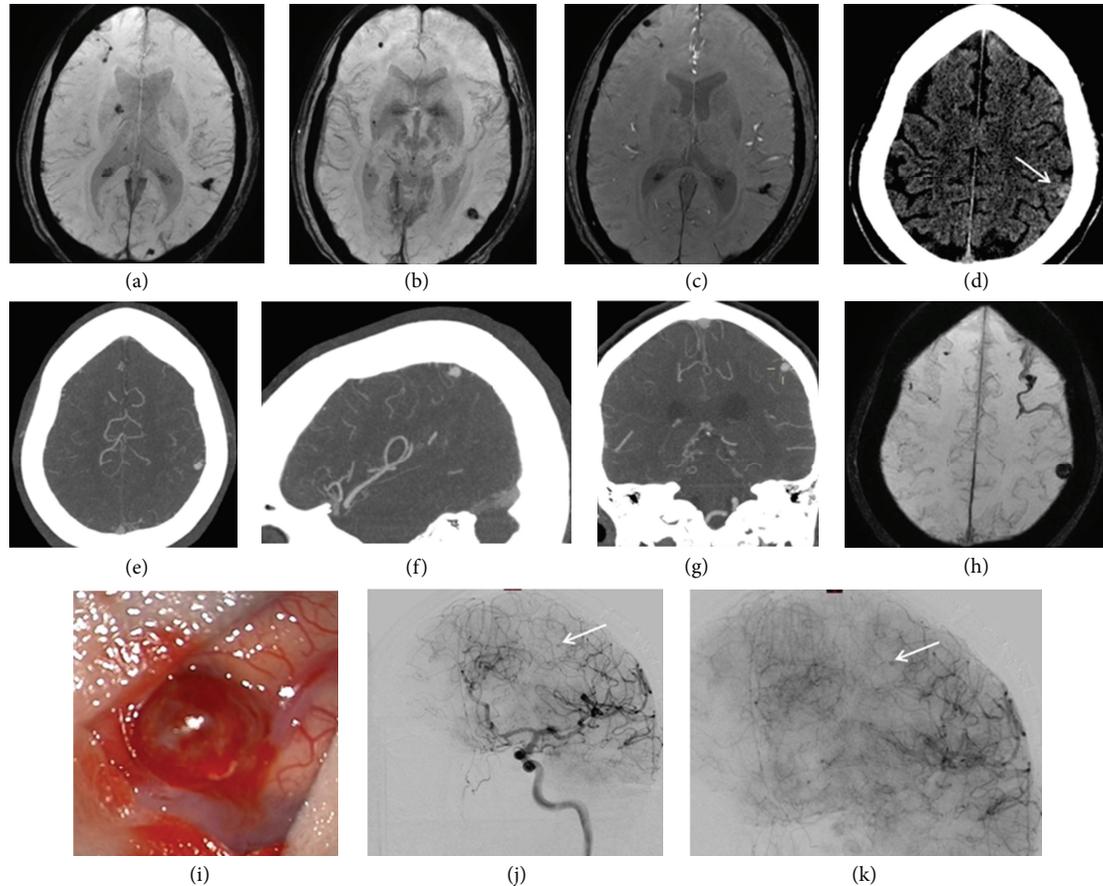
A patient with a history of intravenous drug abuse was admitted to an outside hospital for treatment of endocarditis. MRI at this time demonstrated multiple cerebral septic emboli and mycotic aneurysms (a–c). Two weeks after initiation of antibiotics, the patient had a significant headache and CT scan demonstrated new hemorrhage in the superior parietal lobe (d). The patient was transferred to our hospital for further care, and CTA and MRI at this time demonstrated 2 persistent mycotic aneurysms with hemorrhage surrounding the 7 mm aneurysm arising from the distal cortical branch from the middle cerebral artery (e–h). As the patient required a cardiac valve replacement and would receive full anticoagulation and had a hemorrhage 2 weeks after initiation of antibiotics, the intervention with the ruptured aneurysm was considered the best course of therapy. Due to the distal nature of the aneurysm, microsurgical removal was deemed the best therapy (i), intraoperative image of cortically based aneurysm). Intraoperative angiogram demonstrated complete resection of the cortically based aneurysm with only the single aneurysm remaining (j, k). Follow CTA demonstrated resolution of the final remaining aneurysm.
